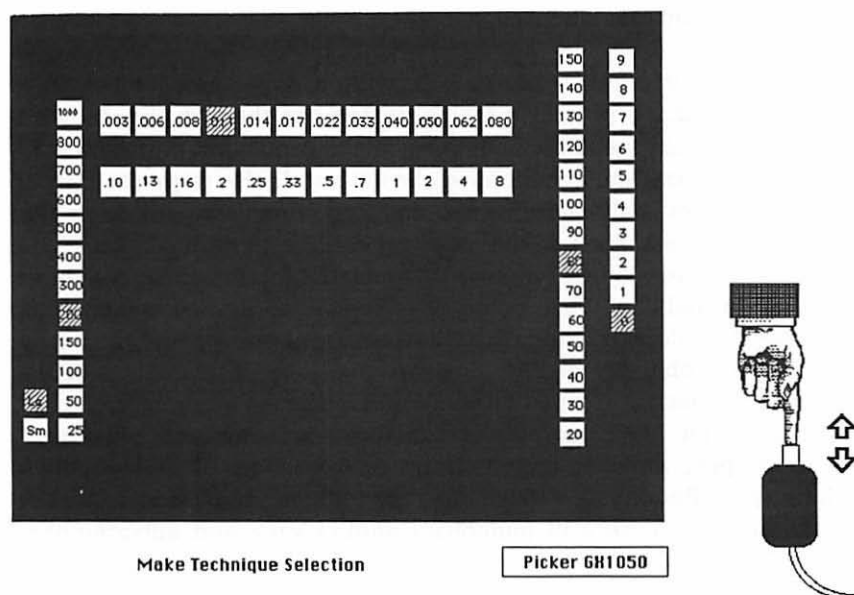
Picker x-ray generator console
